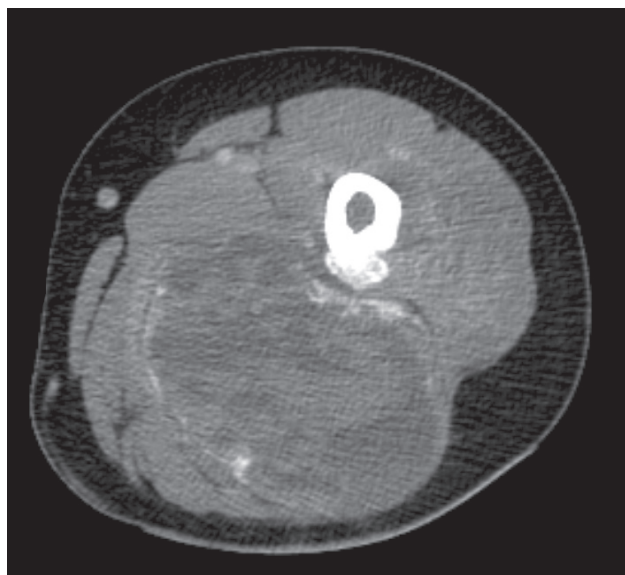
Computed tomography of the thigh reveals a soft-tissue mass located in the posterior thigh, with thin rim calcifications (axial plane)
